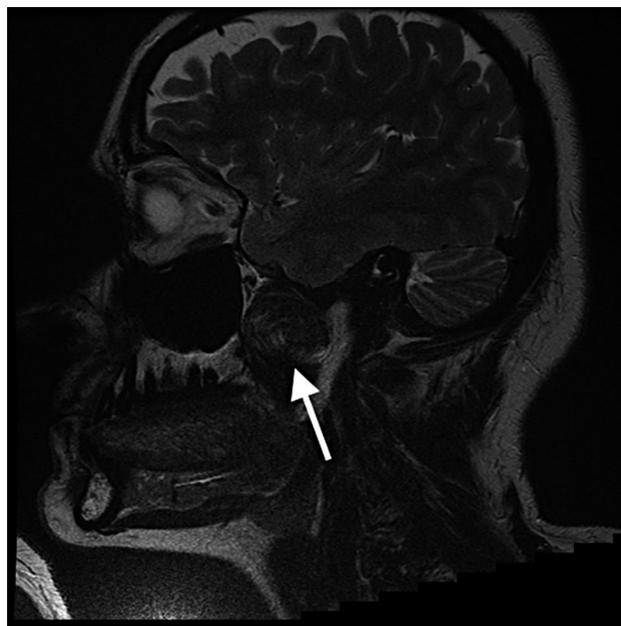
Sagittal MRI scan showing the left mandibular metastasis (white arrow).
